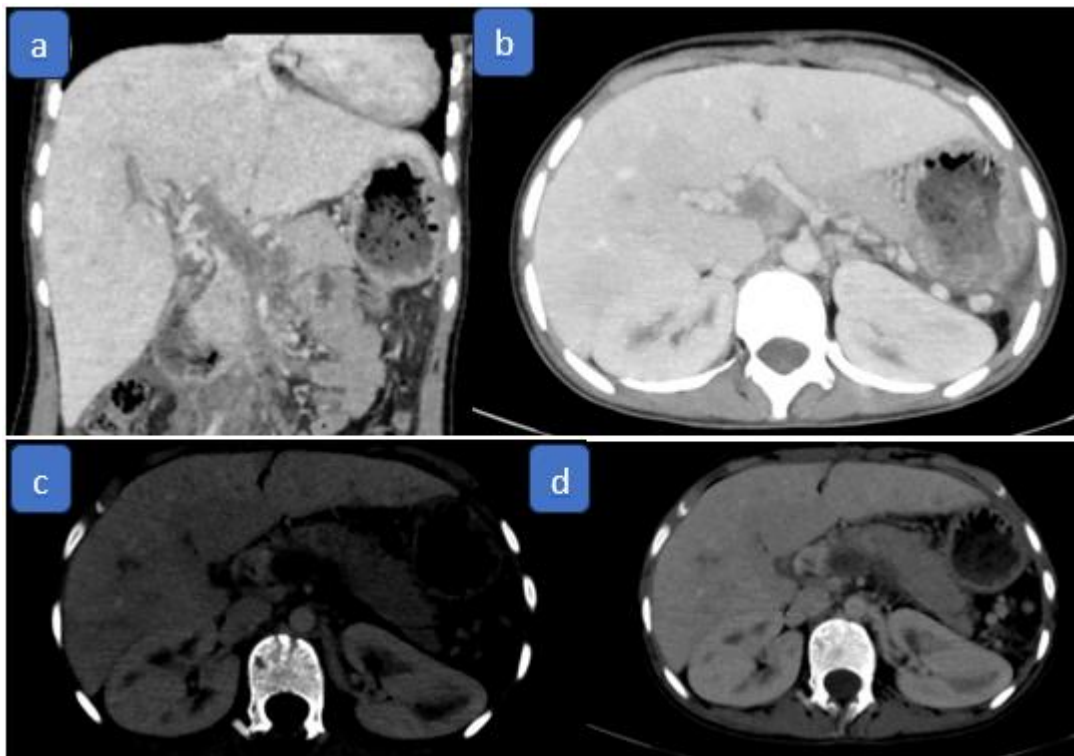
Coronal and axial CT scans during portal phase showing extensive portal vein thrombosis with development of a portal cavernoma. Axial CT in arterial phase shows heterogeneous hepatomegaly with visible bile ducts. Splenectomy site with splenosis nodules is also noted.
